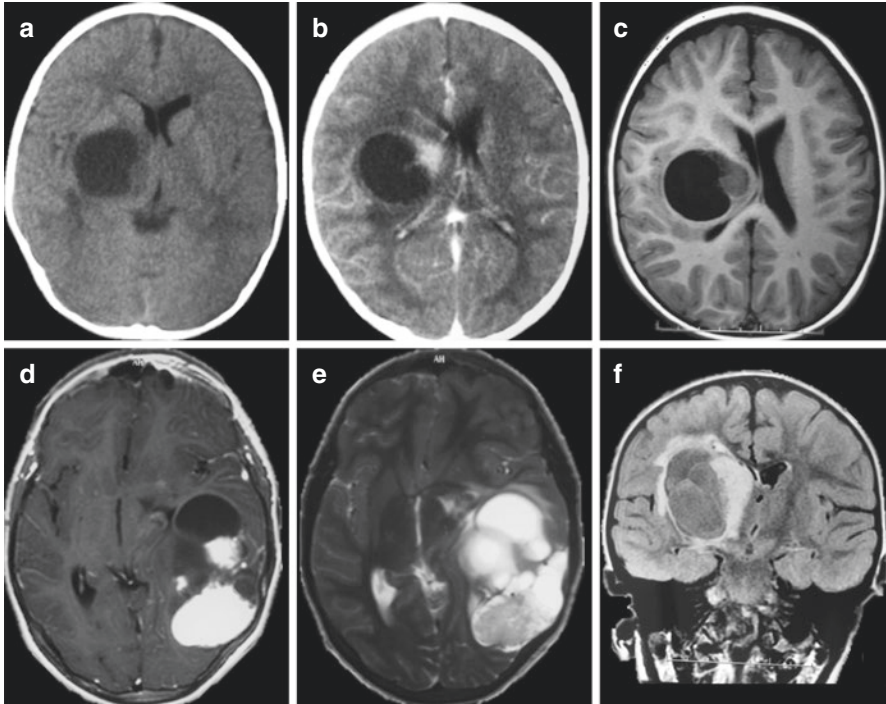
(a–f) Pilocytic astrocytoma: (a) pre-contrast CT scan; (b) post-contrast CT scan; (c) T1-weighted non-contrast MRI scan; (d) T1-weighted post-gadolinium; (e) T2-weighted; (f) coronal FLAIR MRI scan
